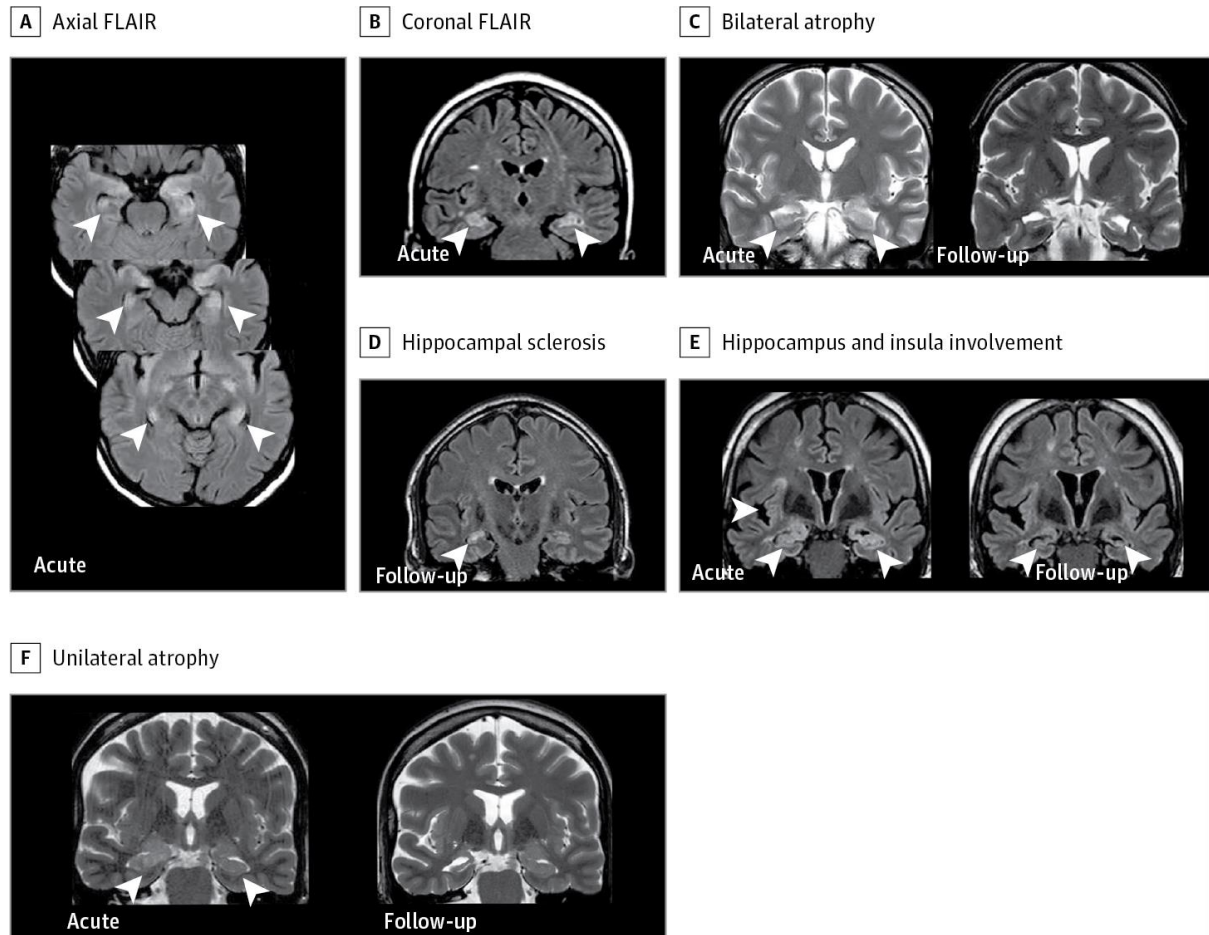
Clinical Magnetic Resonance Imaging (MRI) Findings in Encephalitis With Leucine-Rich, Glioma-Inactivated 1 (LGII) Antibodies. Representative MRIs of patients with anti-LGII encephalitis during the acute stage (median, 17 days after onset) and during follow-up (median, 23.3 months after onset). A, Axial fluid-attenuated inversion recovery (FLAIR) imaging shows signal hyperintensities in both hippocampi and amygdalae during the acute phase. B, Coronal FLAIR image of another patient showing swelling and signal hyperintensity in both hippocampi. C, T2-weighted imaging showing hippocampal edema and enlargement during the acute phase evolving into bilateral hippocampal atrophy. D, Follow-up stage in one patient showing the transition into hippocampal sclerosis of the right hippocampus with gliosis and increased signal in T2. E, Swelling and hippocampal enlargement in one patient showing also an involvement of the right insula and transformation into hippocampal atrophy (follow-up image). F, T2-weighted imaging showing hippocampal edema and enlargement during the acute phase evolving into unilateral hippocampal atrophy. Arrowheads indicate hippocampal and insula imaging changes.
